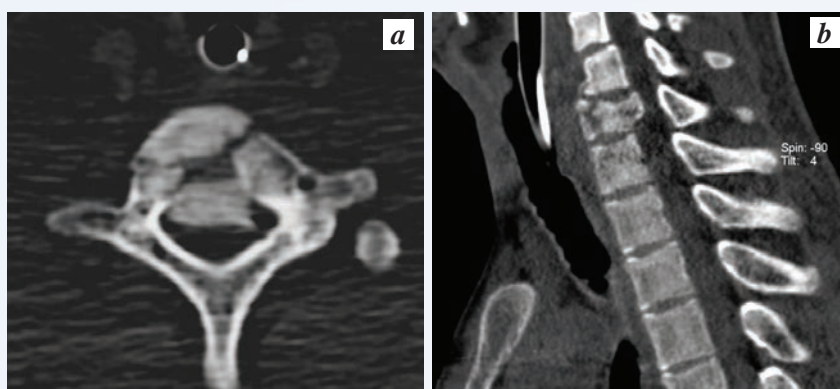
Reconstruction of non-contrast CT of the cervical spine: a – axial; b – sagittal. The white arrow shows C₇ body fracture with 50% narrowing of the spinal canal.
